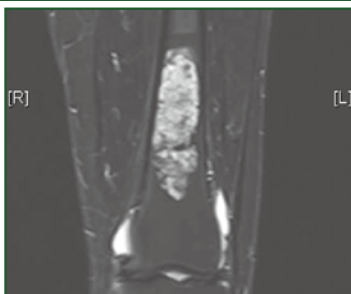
T2W coronal MR image with fat suppression of the same lesion. The lesion demonstrates background hyperintense signals with focal signal drop out, signifying calcifications.
